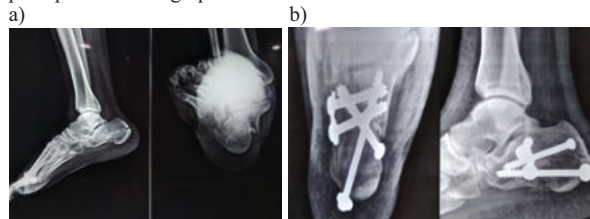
a) preoperative radiographs b) postoperative radiographs
